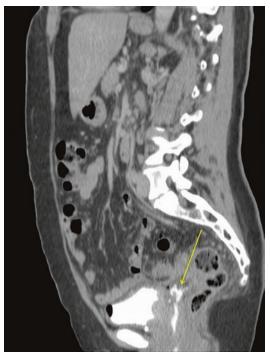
CT urography can be an excellent imaging modality when evaluating for the presence of fistula. Here, a communication can be seen (*arrow*) between the distal ureter and vagina
